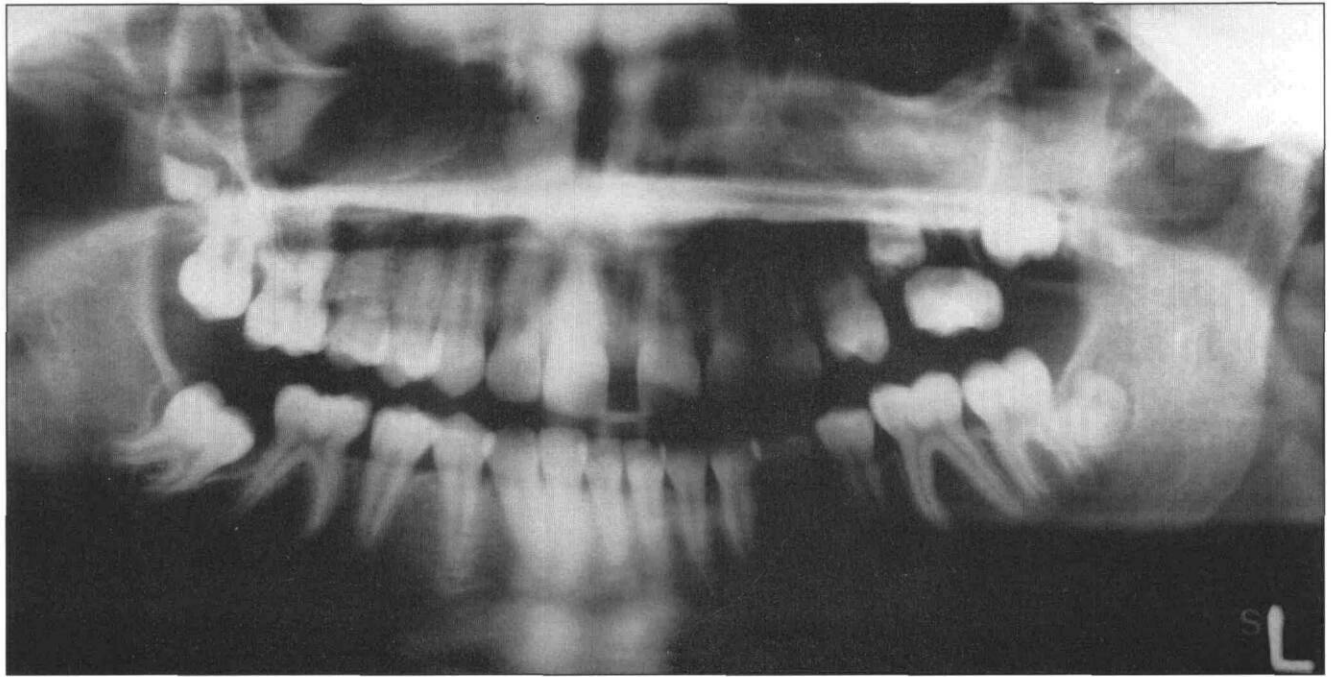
Panoramic radiograph showing agenesis of the roots of the maxillary left second premolar and first and second molars. Abnormal mesial angulation of the mandibular second right molar with dilacerated roots and follicular cyst were noted.
